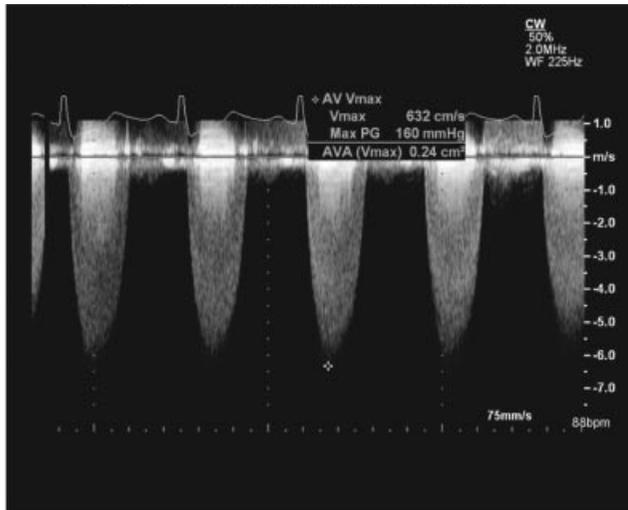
Continuous-wave Doppler echocardiography in severe aortic stenosis – the peak velocity is nearly 6 m s^{-1} (equivalent to a trans-valve pressure gradient of $\sim 140 \text{ mmHg}$).
